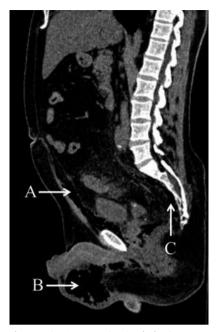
CT scan (sagittal slice). Arrow A: Presence of gas in the extraperitoneal retropubic space. Arrow B: Presence of gas in the scrotum. Arrow C: Presence of extraperitoneal gas in the presacral space.
